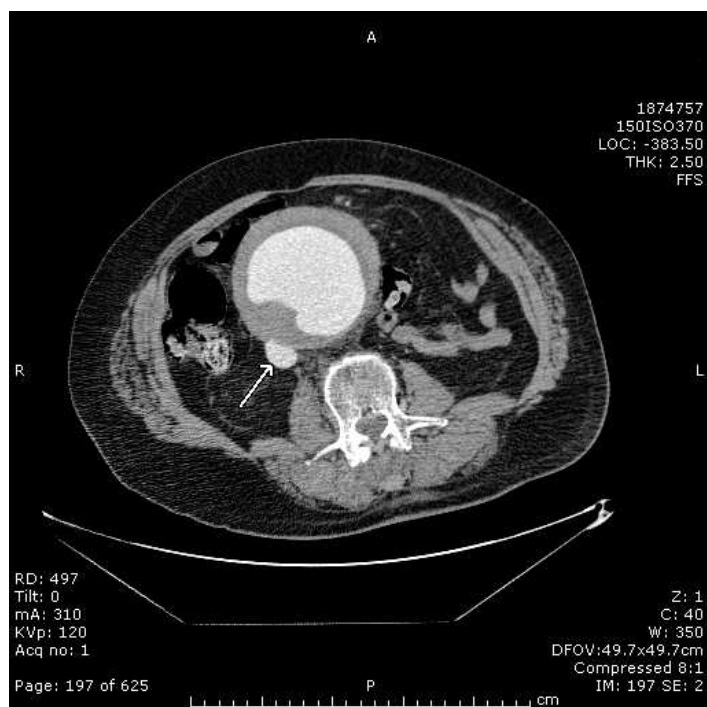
Computed tomography of the abdomen with contrast opacification of the inferior vena cava suggesting an aortocaval fistula.
